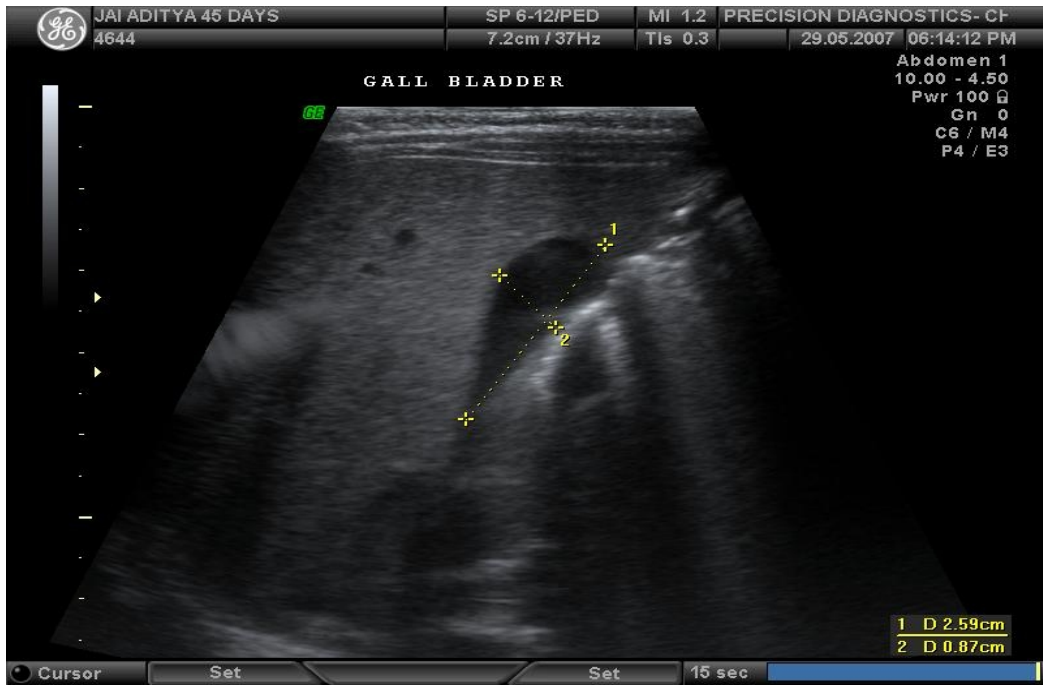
Ultrasonogram showing normal gall bladder
